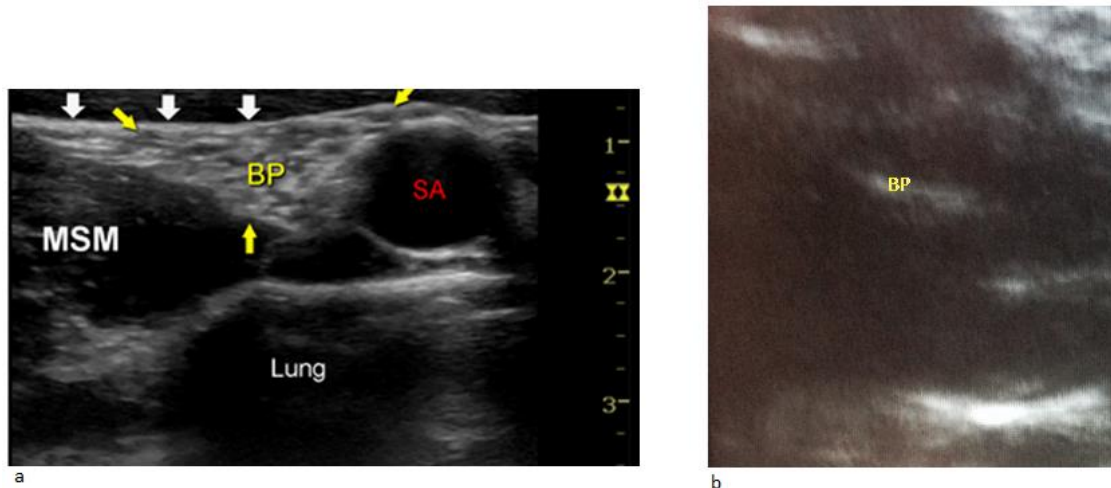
(a) An ultrasound of the actual anatomy of the area surrounding the brachial plexus. (b) The brachial plexus of the second iteration of our model.
